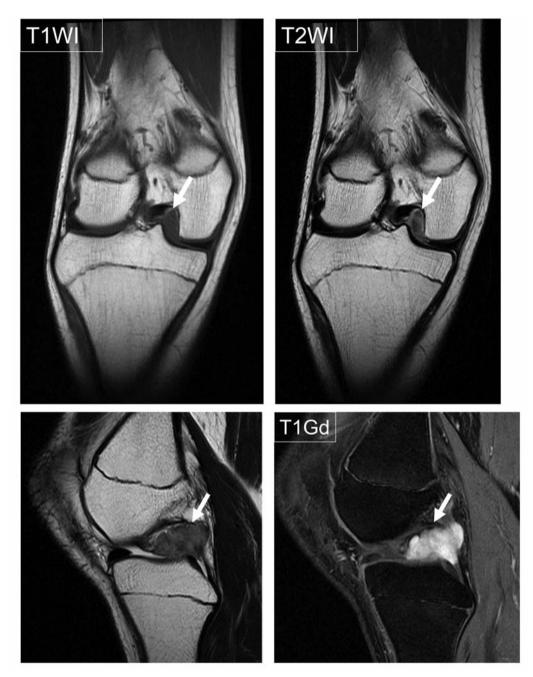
An MR image taken at the initial visit to our Hospital. Recurrent tumor was found in the intercondylar fossa adjacent to medial condyle, with the same intensity of the primary tumor and strong enhancement with gadolinium on T1-weighted image.
